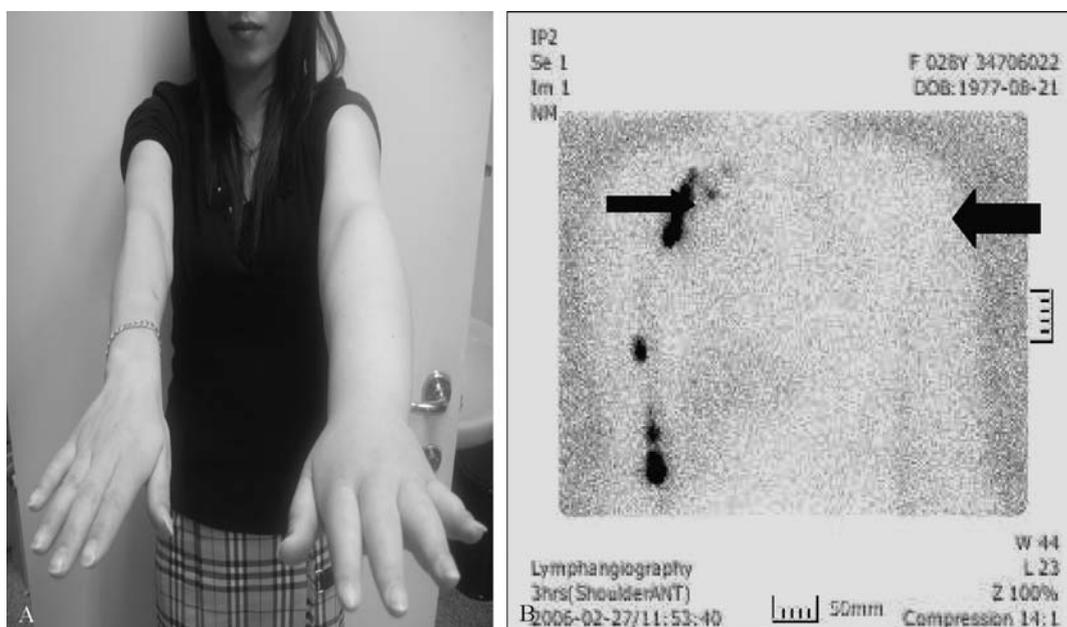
A) Photograph of the patient's left upper extremity at the time of her initial visit to our department. Swelling can be observed on the left upper extremity. B) Upper extremity lymphoscintigraphy obtained three hours after injection of radionuclide reveals markedly delayed and diminished flow in the left upper extremity, with no lymphatic trunks and axillary lymph nodes imaged (thick arrow), compared with the uptake on the right side (thin arrow).
